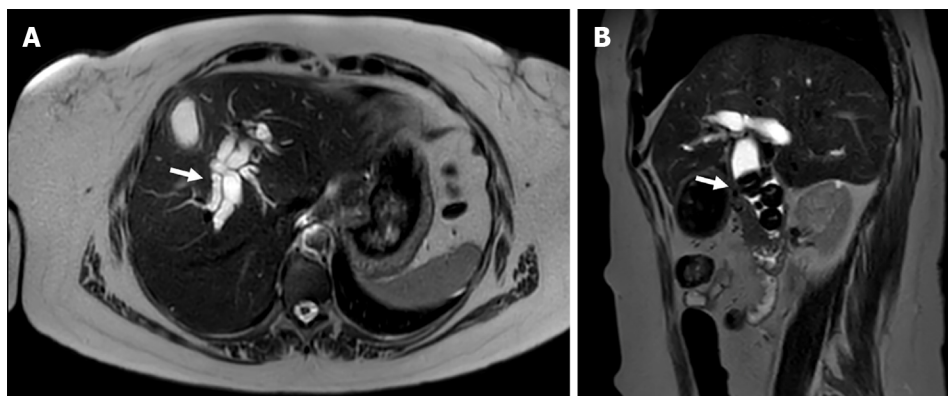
Distal choledocholithiasis in a 53-year-old man with acute secondary cholangitis. A: Axial magnetic resonance T2-weighted images depicts intra- and extrahepatic biliary ductal dilatation; B: Multiple void signal images within the lumen of the common bile duct.
